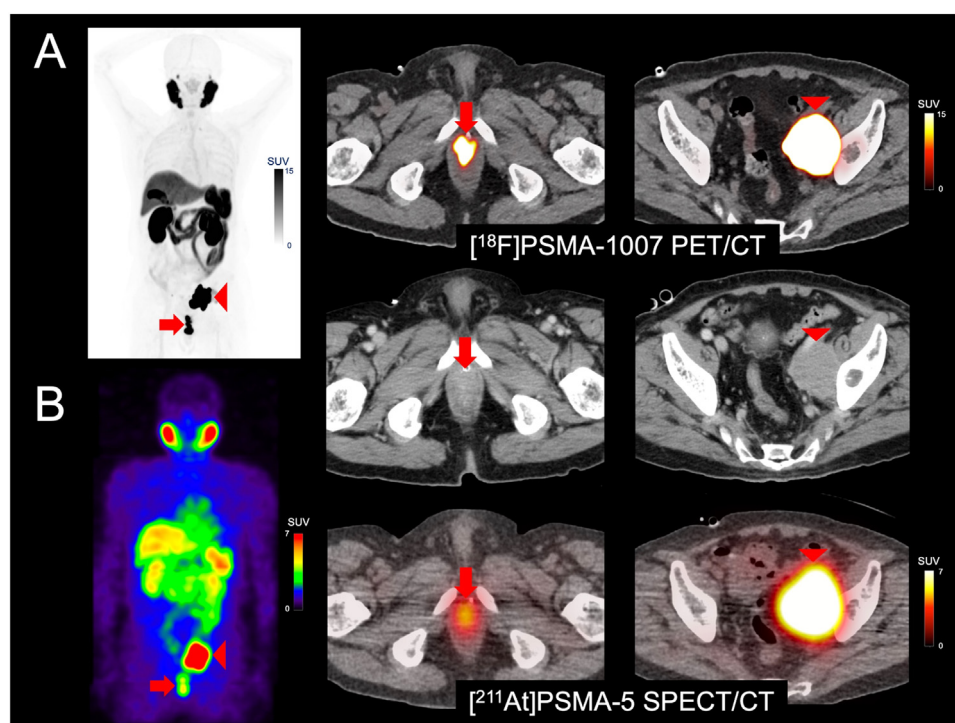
(A) [^{18}F]PSMA-1007 PET/CT and (B) [^{211}At]PSMA-5 SPECT/CT: maximum intensity projection (left) and fusion images (right). Contrast-enhanced CT images are shown in the middle. Both images showed high accumulation in the soft tissue mass in the prostate area (SUVmax=60.7 on [^{18}F]PSMA-1007 PET and 4.9 on [^{211}At]PSMA-5 SPECT) (arrows) and in the enlarged left external iliac lymph node metastasis (SUVmax=143.7 and 17.6, respectively) (arrow heads).
